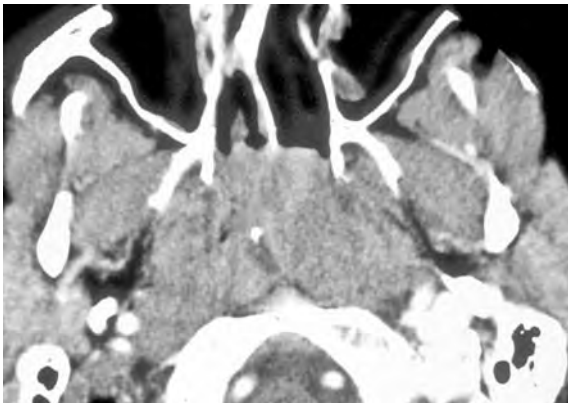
Nasopharyngeal NHL. Axial contrast-enhanced CT shows a bulky mucosal mass filling the nasopharyngeal lumen and extending bilaterally into the choanae. *Note* the parapharyngeal fat is intact and there is no bony invasion of the clivus
